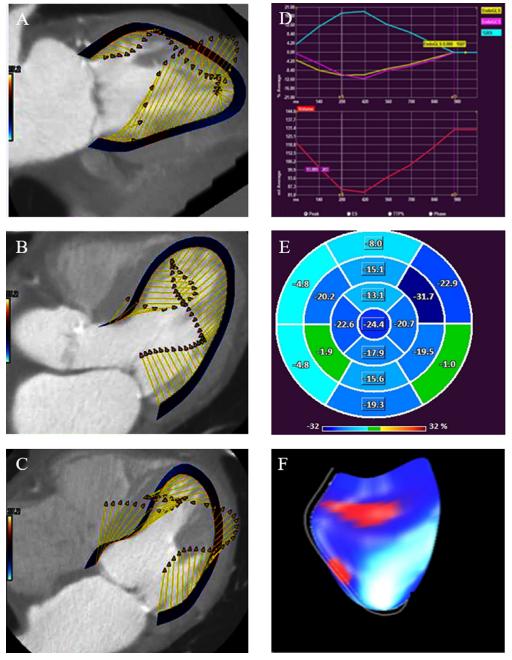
Assessment of left ventricular global longitudinal strain with feature tracking multi-detector row computed tomography. MDCT feature tracking in left ventricular 2-chamber (panel A), 3-chamber (panel B) and 4-chamber (panel C) views formatted via multiplanar reconstruction and processed with the help of QMass. After analysis in QMass, strain plots (Panel D), bull's eye (panel E) and dynamic MDCT 3D images (Panel F) are derived. Abbreviations: MDCT = multi-detector row computed tomography.
